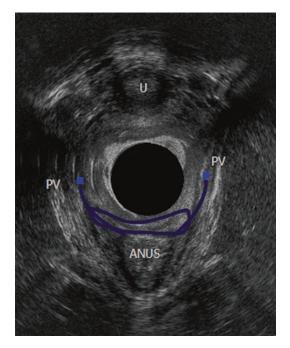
Endovaginal ultrasound with the vagina and the pubovisceral muscles of the pelvic floor
